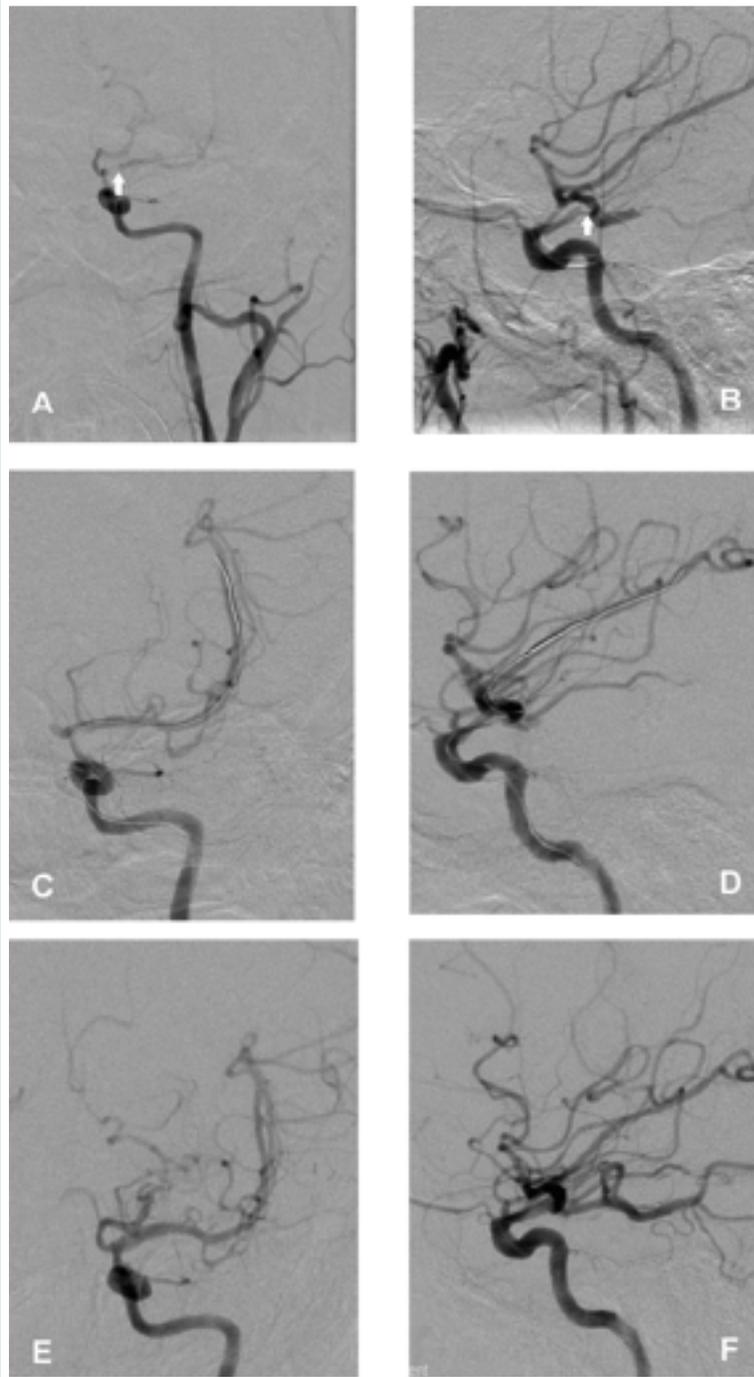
These two figures demonstrate successful dilation of a >90% stenosis in the left middle cerebral artery of a 53-year-old woman who had been having multiple left hemispheric TIAs (mini-strokes) while on maximal medical therapy. After balloon angioplasty, a Wingspan™ stent (radiographic markers denote the proximal and distal boundaries) was inserted to optimize the vessel lumen. Figures 2A and 2B show the >90% stenosis in the proximal M1 segment of the left middle cerebral artery (white arrows). Figure 2A is in the anterior-posterior projection (front view), and Figure 2B is in the lateral projection (side view). Figures 2C and 2D show the balloon catheter and microwire across the stenotic lesion and how the vessels have improved in size post-angioplasty. Figures 2E and 2F show the final result post-balloon angioplasty and Wingspan stent placement with no residual stenosis in the left middle cerebral artery.
